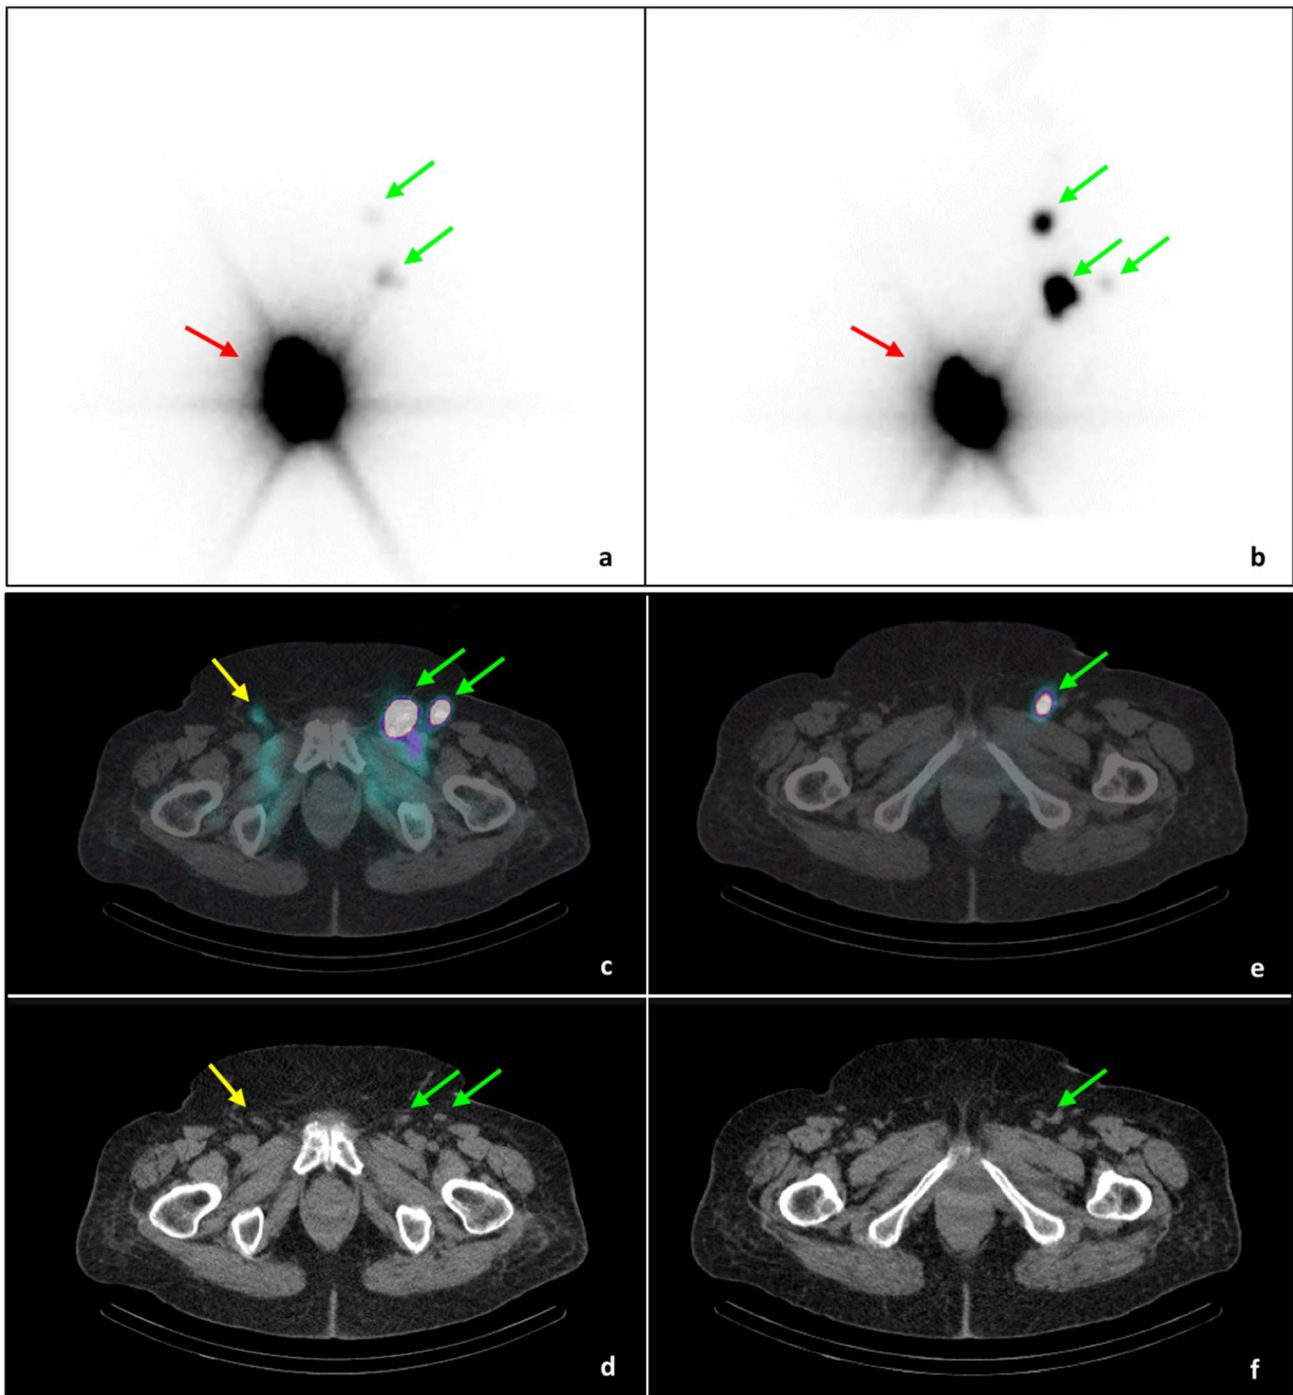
Lymphoscintigraphy of an 88-year-old patient with newly diagnosed vulvar squamous cell carcinoma of the left labium majus and the periclitoral region bilaterally (clinical case #3). a, b Planar static images, anterior views (a early, b late) of the pelvis. c–f SPET/CT images (dual-head gamma-camera system, Symbia Intevo 2, Siemens, Germany): c, e axial fused SPET/CT; d, f axial co-registered CT. (red arrow: site of intradermal injections of ^{99m}Tc -nanocolloids
